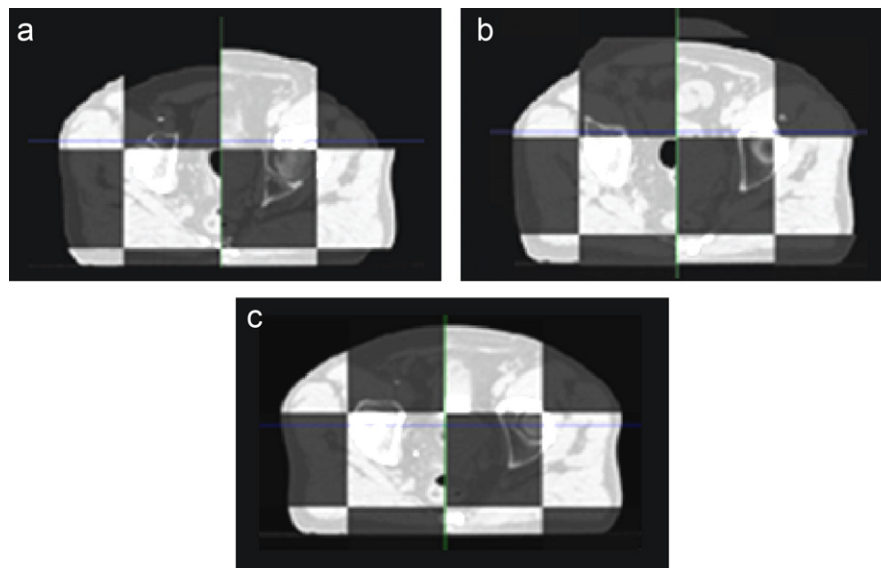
Checkerboard views of a computed tomography (CT) template (white) and an individual's computed tomography (a) before registration, (b) after a restricted block matching (RMA) registration and (c) after a free-form deformation (FFD) registration (dark gray).
